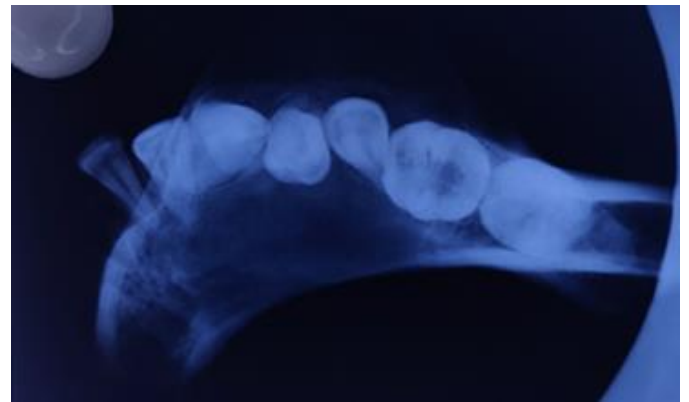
Occlusion radiograph showing intact cortical plates.
